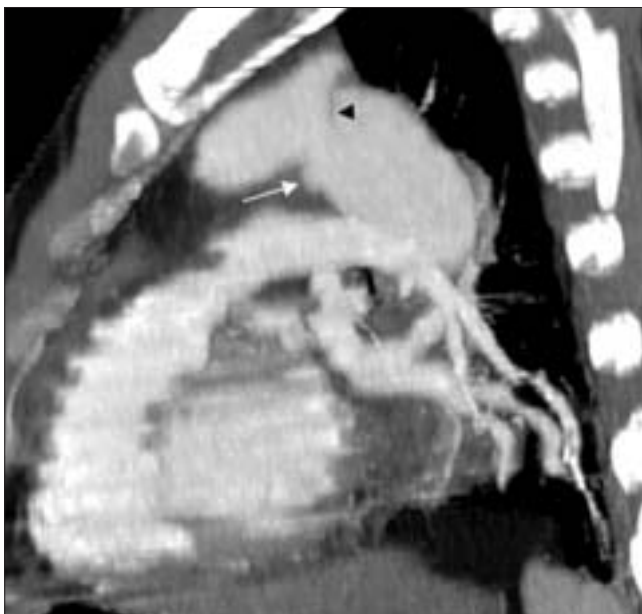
Oblique-sagittal reformatted CT image shows a sacular outpouching at the junction of arcus aorta and descending aorta (*arrow*) and intimal flap (*arrowhead*).
